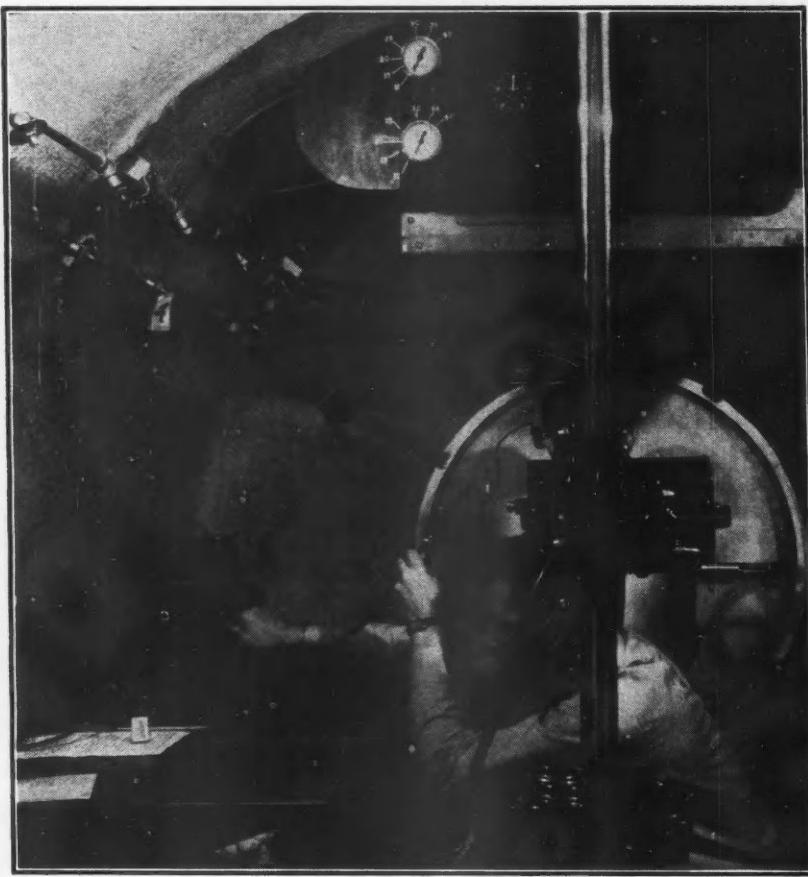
Showing the arrangement inside the chamber for taking x-rays of the chest at altitude, and also for measuring blood oxygen saturation.
